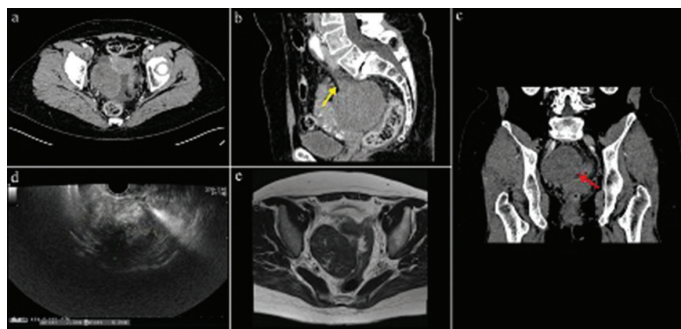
Radiological findings of the patient. (a-c) Contrast-enhanced computed tomography scan of the abdomen and pelvis showing a dark fan sign (fan-shaped poor contrast enhancement within the uterus next to the fibroid) (red arrow), indicating the necrotic pedicle of the uterine fibroid (yellow arrow) (a, axial view; b, sagittal view; c, coronal view). (d) Transvaginal ultrasound image showing a pelvic mass suggestive of 70 x 60-mm uterine fibroids. (e) Magnetic resonance imaging suggesting a uterine fibroid with a twisted pedicle.
